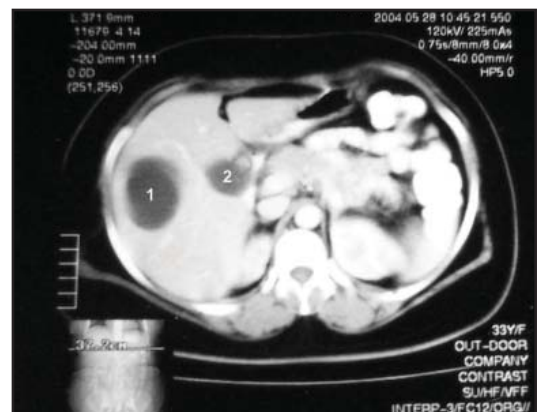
CT scan of abdomen shows (1) cyst in segment VI of liver and (2) calculus in the neck of gall bladder
